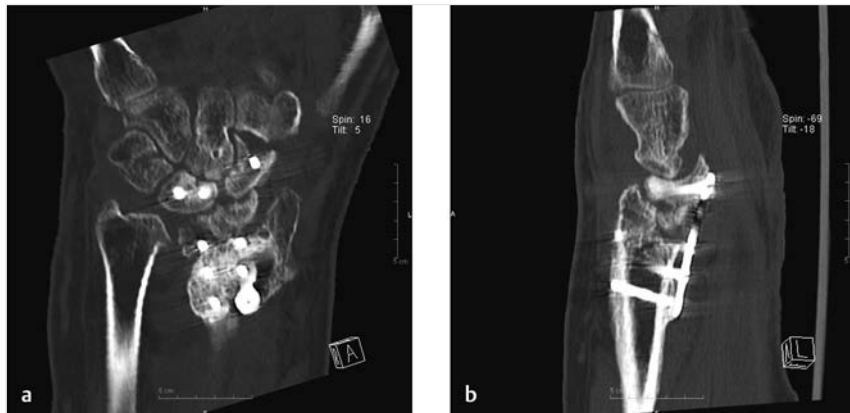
(a, b) The CT scan showed that the lunate was fixed in a dorsal intercalated segment instability position. Within this short period of time, painful midcarpal osteoarthritic changes occurred with subchondral cysts. The head of the capitate is subluxated dorsally.
